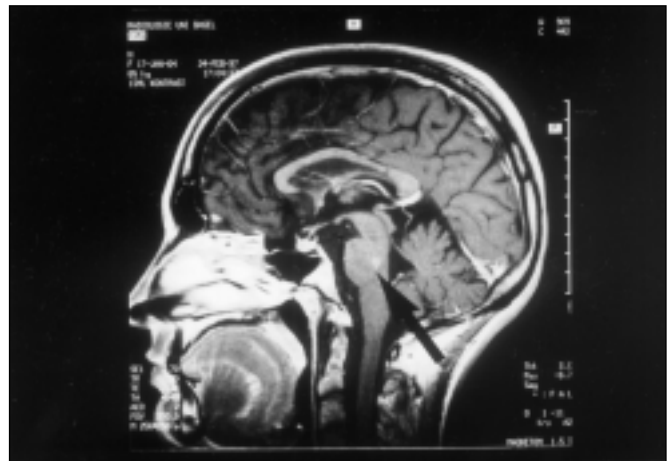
MRI (1997) of the pons with a hyperintensive lesion in a T1 weighted image enhanced with gadolinium.
